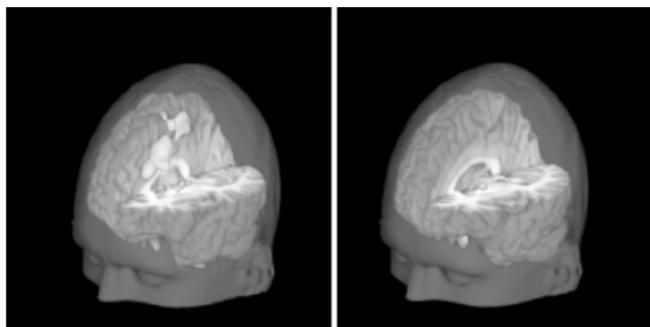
Functional MRI scans show brain response in pain-sensitive (left) and nonsensitive (right) patients. (Reproduced by permission of the author from: Coghill RC. *Brain mechanisms of pain: Overview. Section on: Neural correlates of inter-individual differences in the subjective experience of pain* [homepage on the Internet]. [cited 2005 Oct 4] Available from: <http://www1.wfubmc.edu/Nba/Faculty/Labs/coghill/Individual+Differences.htm>.⁵)
